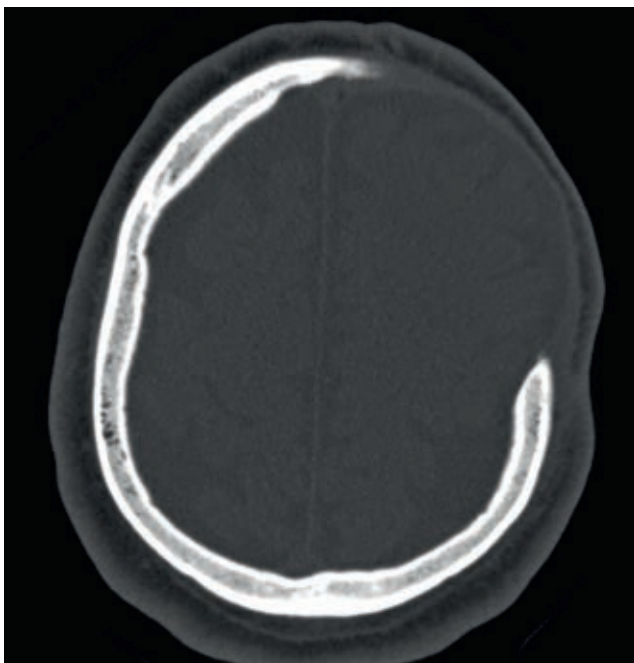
Axial slice of the CT-scan of the skull contour without patient specific implant
